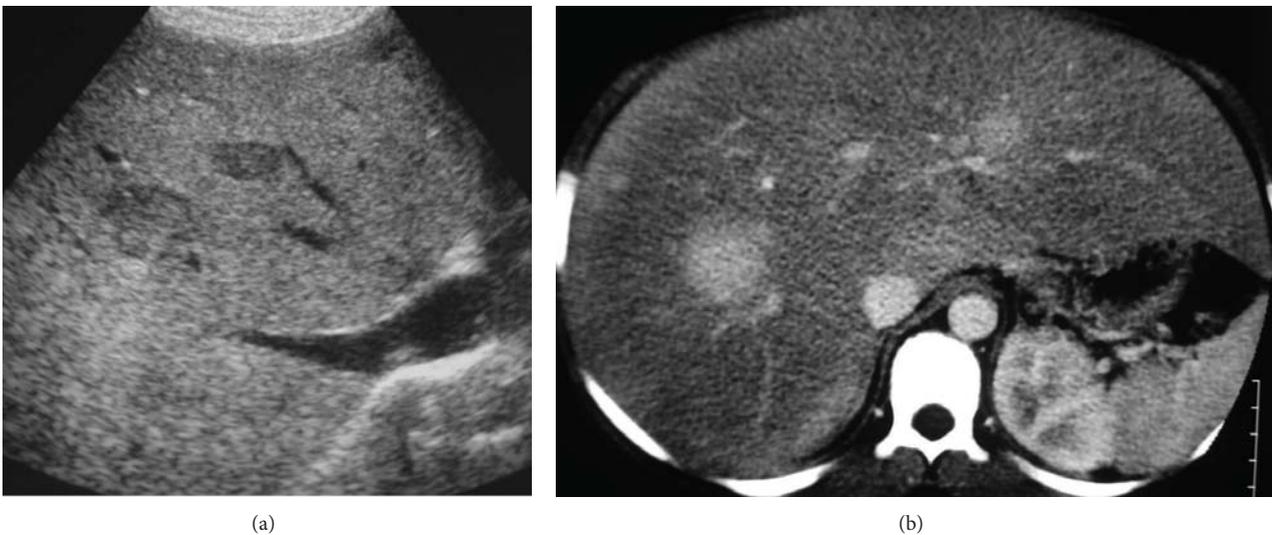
Fourteen-year-old boy with glycogen storage disease type I and multiple HCA measuring from 1 to 3 cm diameter. (a) US shows an enlarged hyperechoic liver (steatotic) with well-delimited hypoechoic nodules. (b) CT performed at the arterial phase after contrast injection shows enlarged steatotic liver with multiple nodules that are strongly enhanced.
